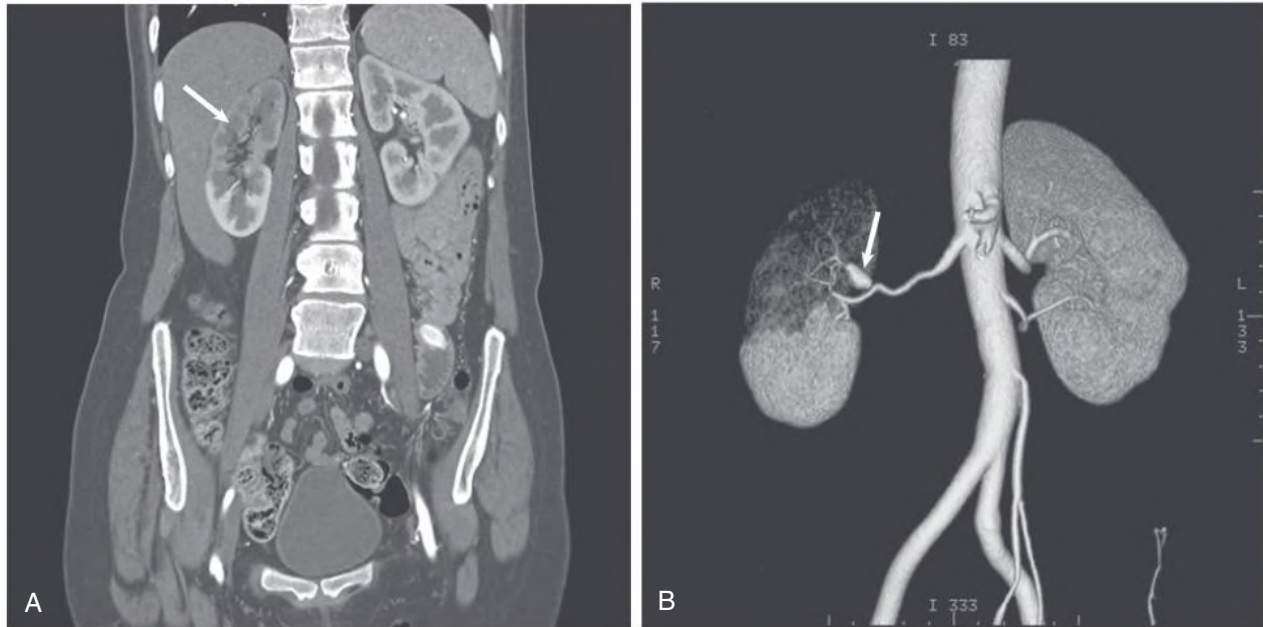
Computed Tomography Angiogram of Renal Artery Aneurysm With Area of Infarction in Right Kidney. (A) Coronal image demonstrates area of intact tissue with no blood perfusion within the kidney parenchyma (arrow). (B) Reconstructed view with vascular aneurysm (arrow) and minimal flow in the distribution beyond this segment consistent with near-total occlusion. This patient presented with accelerated renovascular hypertension treated primarily with renin-angiotensin system blockade.
